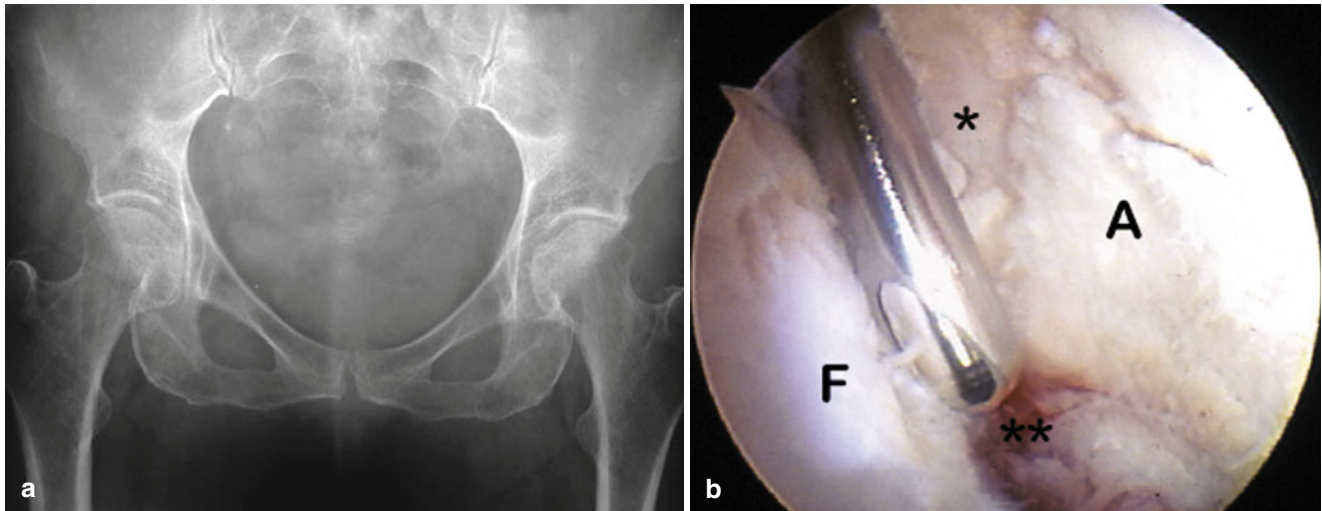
(a) AP pelvis radiograph of a 74-year-old woman with chronic rheumatoid arthritis who presented with recent onset of intrac-table mechanical hip pain. Radiographs were reported as superficially normal with only modest evidence of inflammatory degenerative changes, insufficient to solely explain the magnitude of her symptoms.
